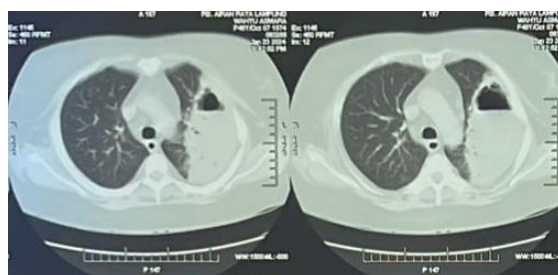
Chest CT scan without contrast showed a well-demarcated lesion measuring 13.1x7.2x11.2 cm, air-fluid level (+), walled 0.5 cm thick that lobulated the lateral part of the apicoposterior segment, anterior of the left superior lobe, left superior lingula, part of the superior, anterobasal, laterobasal segments of the inferior lobe of the left lung suspected of lung abscess.
